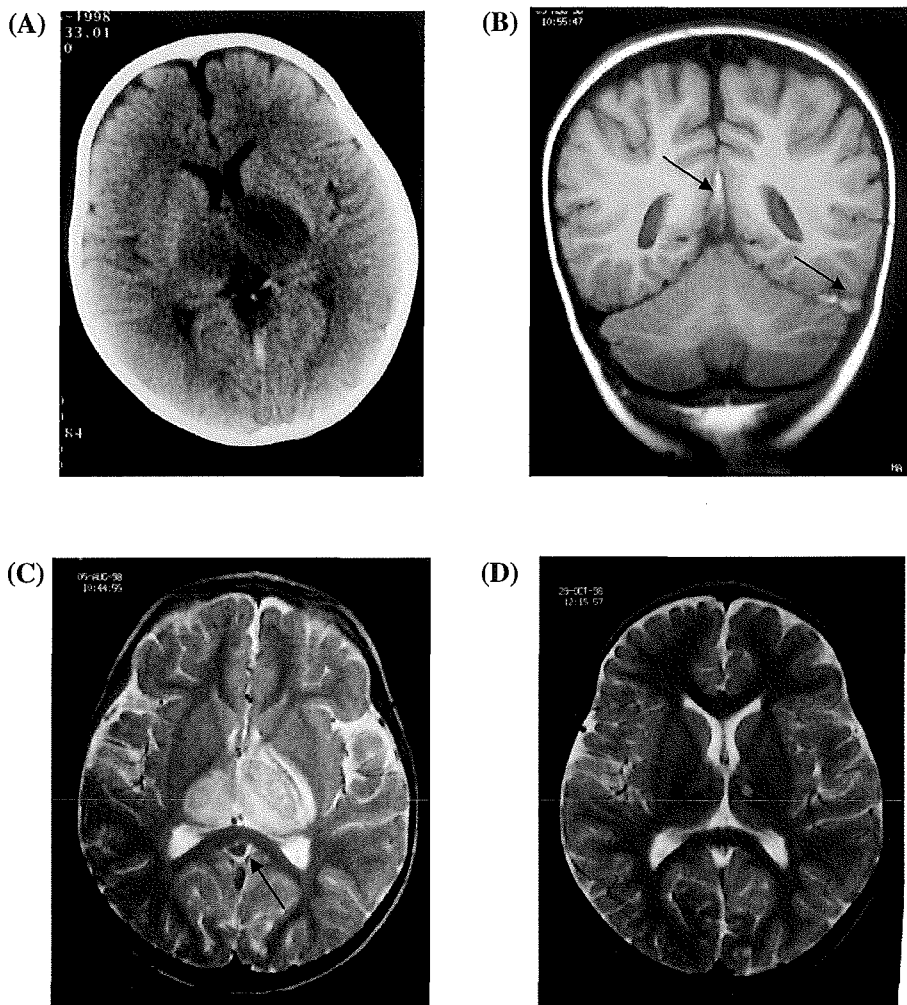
Neuroimaging from a 20-month-old girl with iron deficiency anaemia. (A) Bilateral thalamic hypodensity and thrombus in the straight sinus and deep cerebral veins are demonstrated on the CT scan. (B) Thrombus in the straight and left transverse sinuses is seen as high signal on the coronal T1-weighted MRI (arrows). (C) The axial T2-weighted MRI shows bilateral thalamic high signal involving the posterior limb of the internal capsule and the posterior putamen. The vein of Galen and straight sinus are dark due to the iron products of haemoglobin (arrow). (D) Follow-up T2-weighted MRI 3 months later demonstrates almost complete reversal of the thalamic infarction, with only a small residual scar, and restored flow in the vein of Galen and straight sinus.
